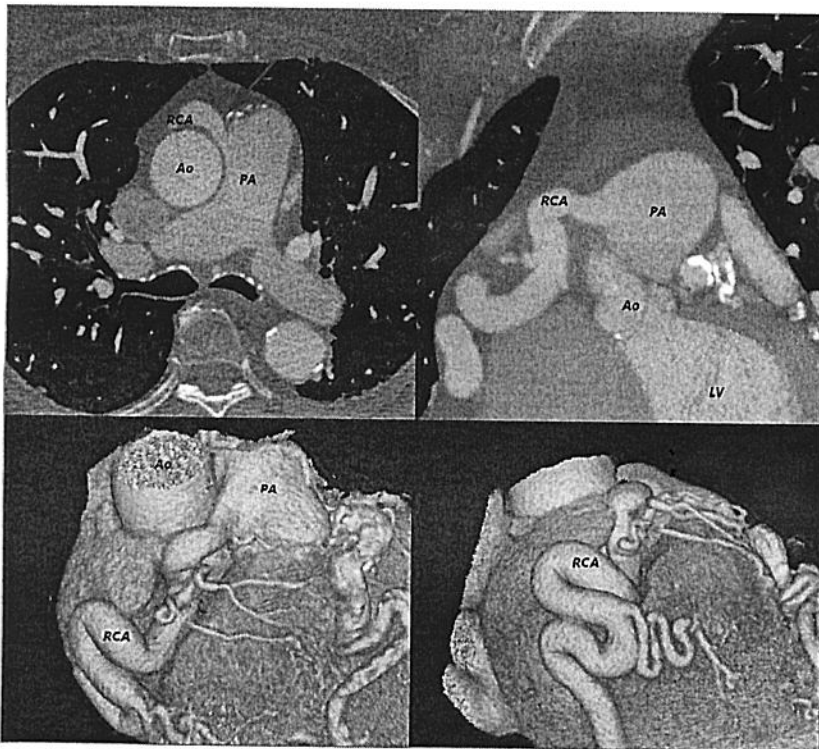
Coronary computed tomography angiography with maximum intensity projection (MIP), multi-planar (MPR) and 3D volumetric reconstructions, revealing anomalous right coronary artery from pulmonary artery (ARCAPA) with extensive dilatation and tortuosity of right coronary artery. Ao = aorta, PA = pulmonary artery, RCA = right coronary artery, LV = left ventricle.
